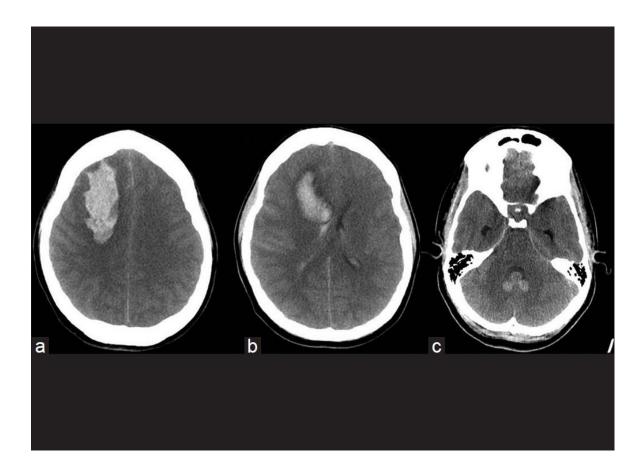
Example of a CT scan of the Brain (Ghaly et. al. 2012).
